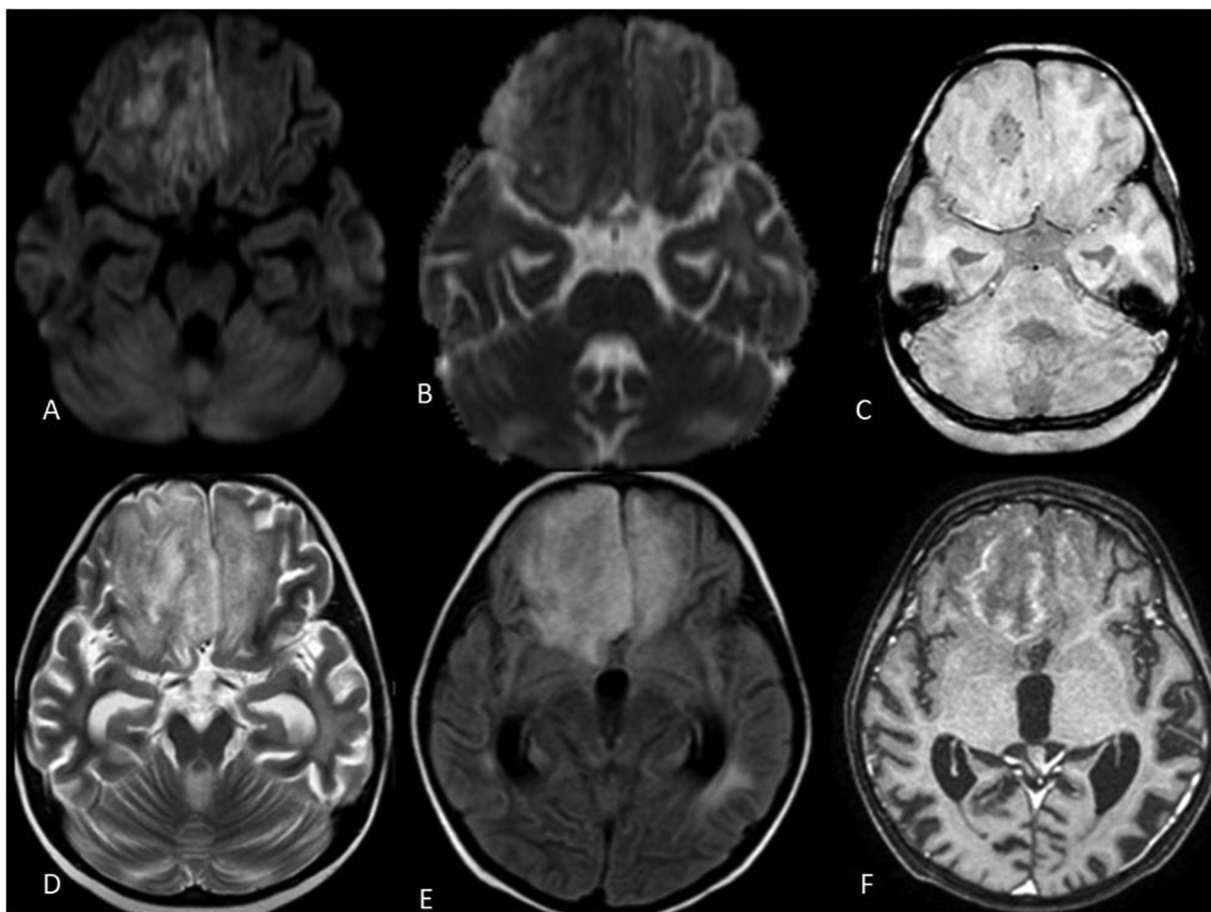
Case 3: (A) Axial diffusion-weighted imaging, (B) axial apparent diffusion coefficient (ADC), (C) axial susceptibility-weighted imaging, (D) axial T2-weighted (T2W), (E) axial fluid-attenuated inversion recovery (FLAIR), and (F) axial postcontrast T1W showing ill-defined heterogeneous lesion involving bilateral basifrontal cortices, right superior frontal cortex, and subcortical white matter. The lesion appears heterointense on T2 and FLAIR images. Patchy areas of restricted diffusion with corresponding low ADC values are seen foci of signal loss with “blooming” are seen within the lesion in right basifrontal cortex, suggestive of hemorrhage. On contrast administration, mild-to-moderate heterogeneous patchy predominantly peripheral enhancement is seen. Mass effect and midline shift are seen.
